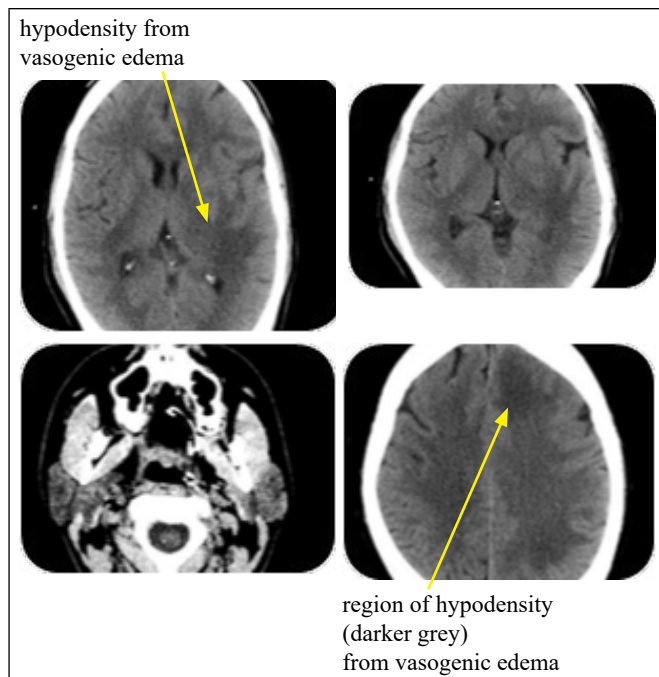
CT head without contrast showing interval development of multifocal hypoattenuating areas in supratentorial brain parenchyma with perilesional vasogenic edema (highlighted with yellow arrows).
